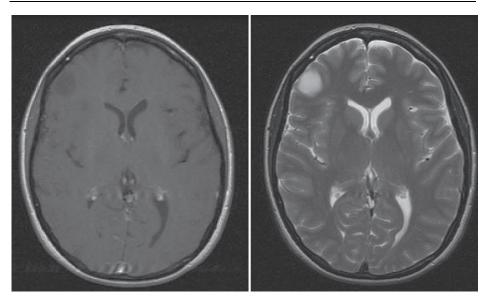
T1-weighted, axial (right) and T2-weighted, axial (left) magnetic resonance imaging (with gadolinium contrast) of a non-contrast enhancing, low-grade astrocytoma in a 41-year-old female patient. (Cha S et al., 2005)
